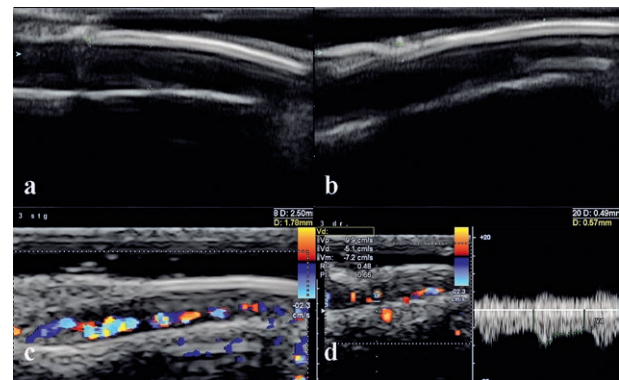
US aspect in a 52 years old female with psoriasis and no clinical affected nails: a) 2D US – thickness of the nail bed; b) 2D US – measurements of the nail plaques thickness; c) color Doppler US – tortuous vessels in the nail bed; d) spectral Doppler – Doppler indices in nail vessels
